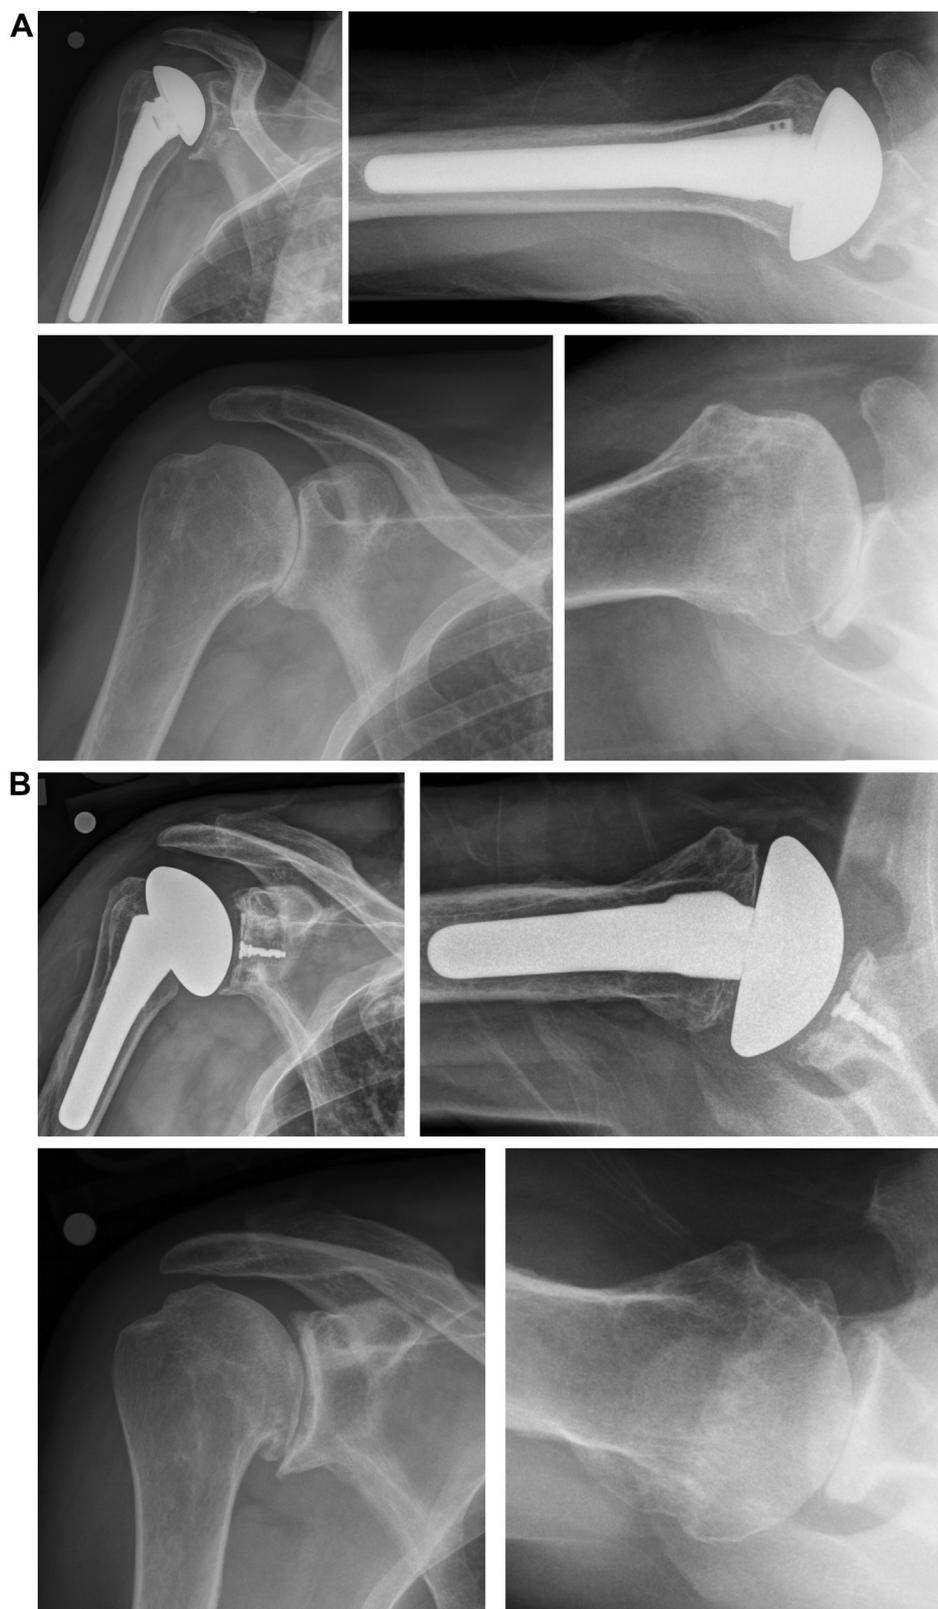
Case examples. An elderly patient (A) with a B2 glenoid deformity who underwent successful anatomic total shoulder arthroplasty (TSA). An elderly patient with severe preoperative posterior humeral head subluxation (B) who also underwent successful anatomic TSA. Pre- and postoperative (A: 3 years, B: 7 years) anteroposterior and axillary radiographs are shown.
